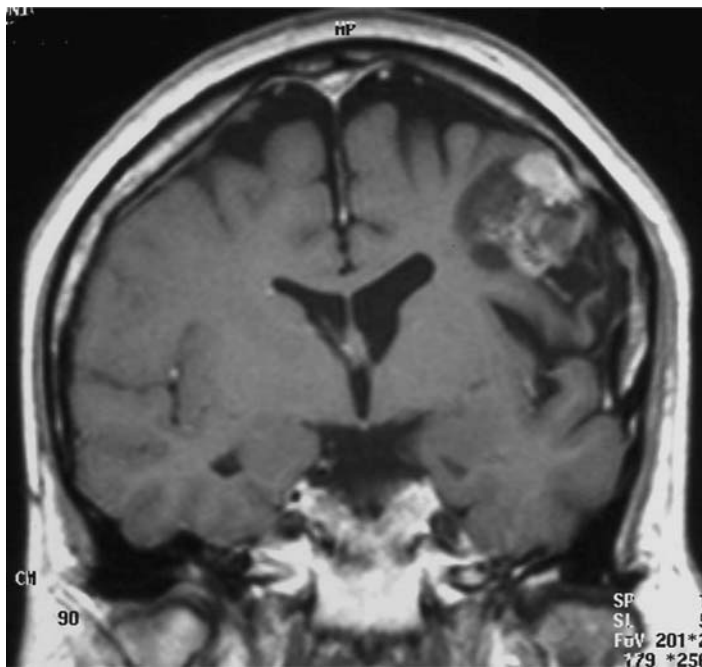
Ganglioglioma, MRI. From the Neuroradiology Unit, Dpt Neuroscience, University of Turin
